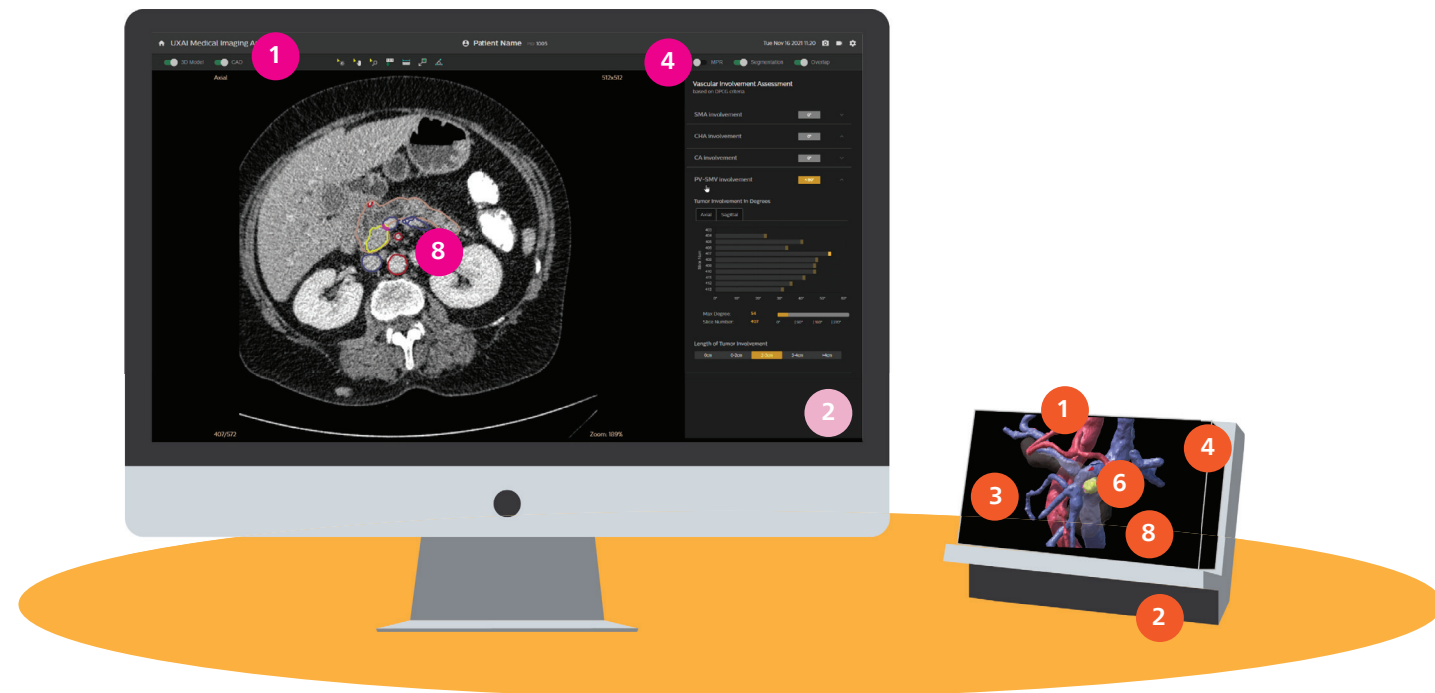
Test set up of the integrated medical workstation; from left to right: CT scans, CAD generated side panel and 3D model in holographic display.
